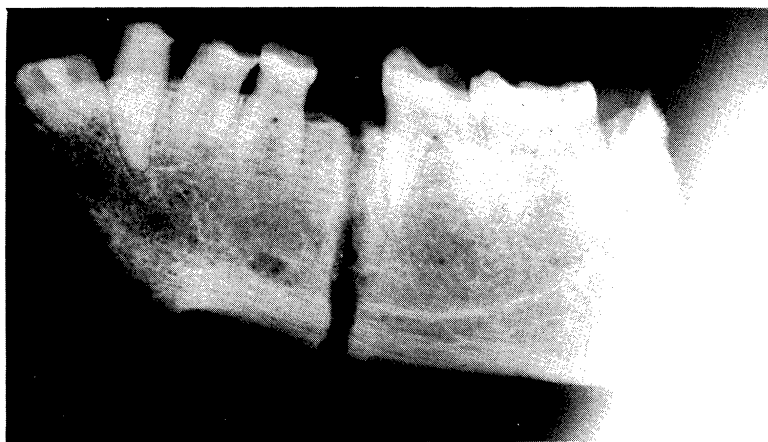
Lateral jaw X-ray six weeks following fracture into which cyanoacrylate monomer was incorporated.
